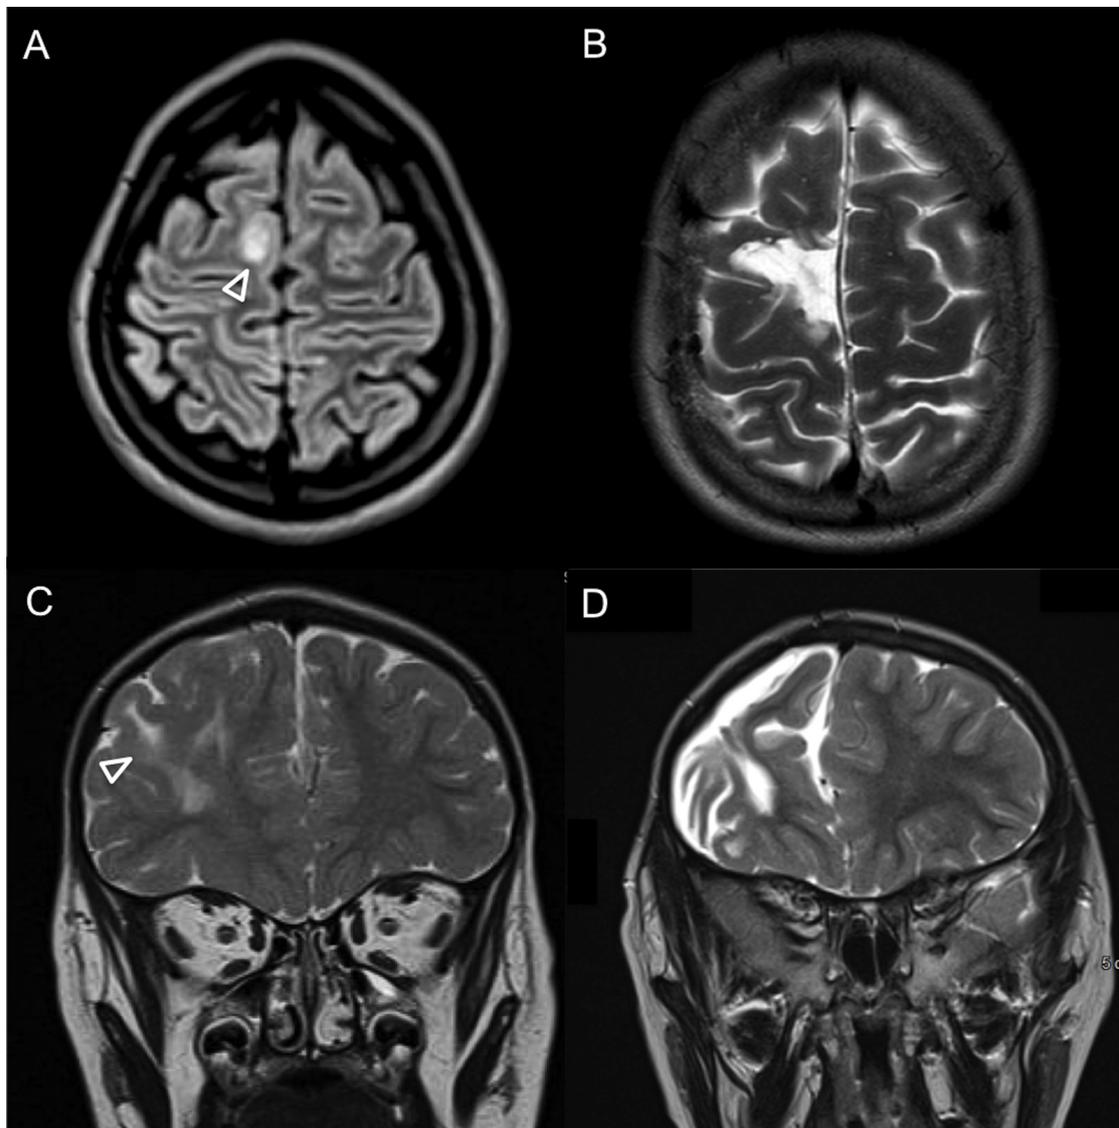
MRI and ioUS findings in a 52 years old male.
